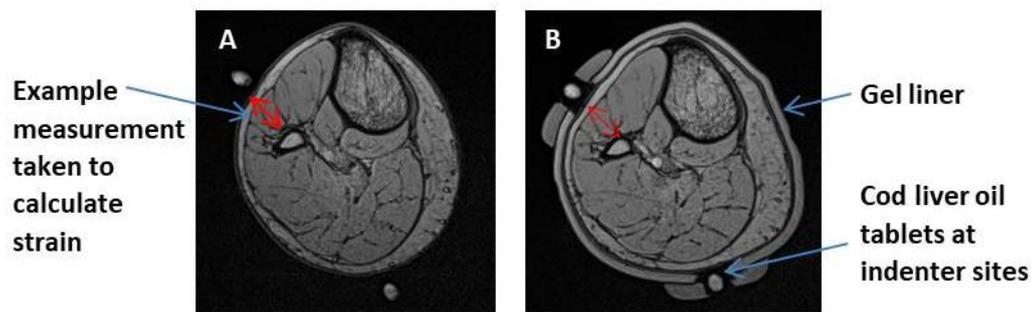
Corresponding transverse section MR images displaying calf of one participant at (A) baseline and (B) loaded with 60 mmHg cuff pressure
